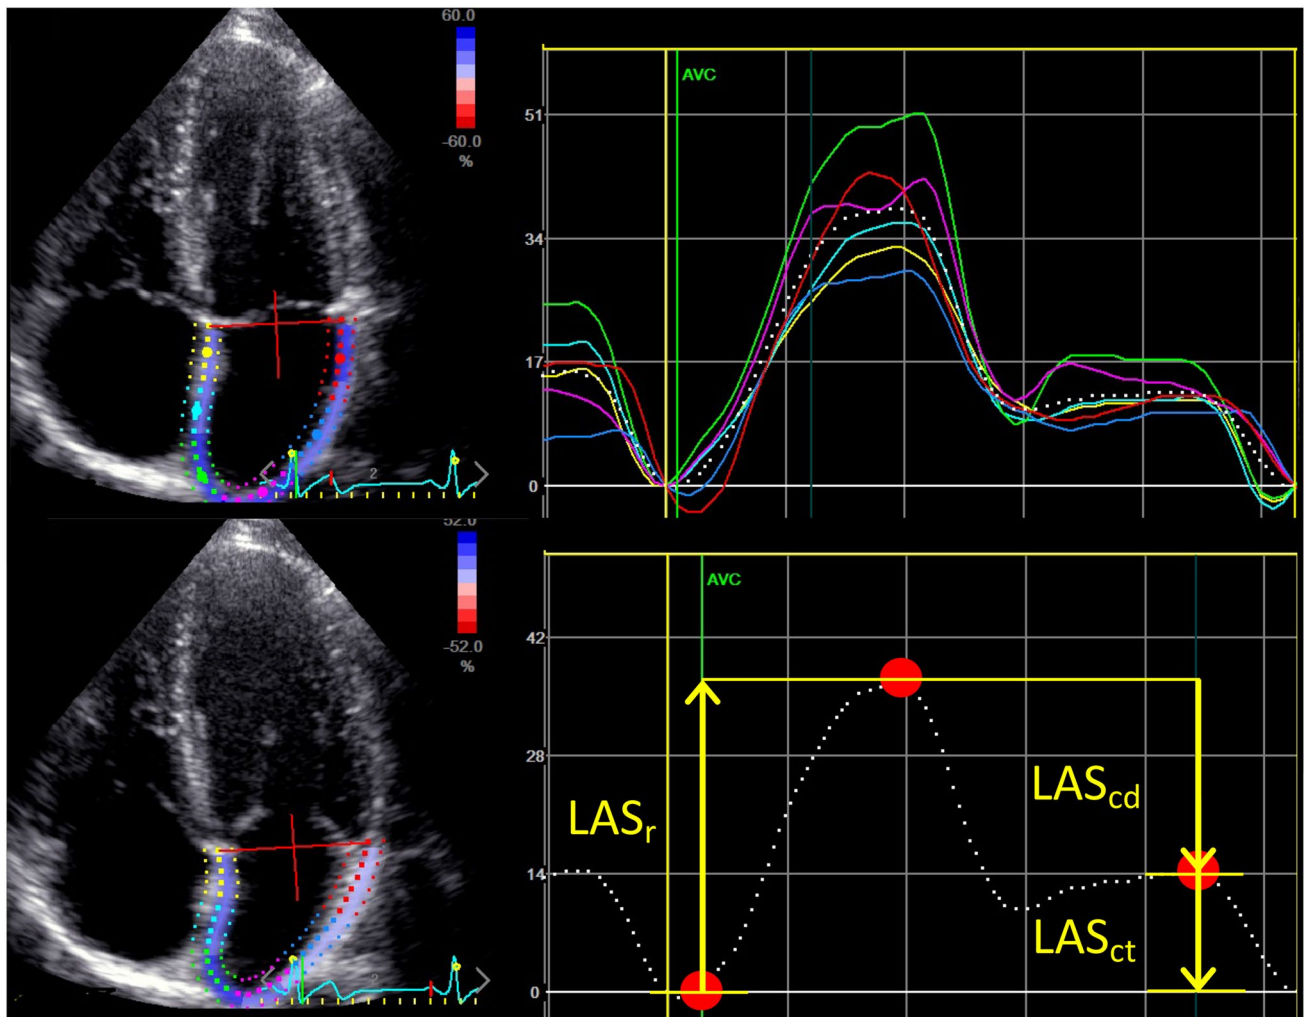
Left atrial strain imaging in the apical 4 chamber view. *AVC* aortic valve closure, *LAS_r* LA reservoir phase, *LAS_{cd}* LA conduit phase, *LAS_{ct}* LA contraction phase, *x-axis* time (ms), *y-axis* LA strain
